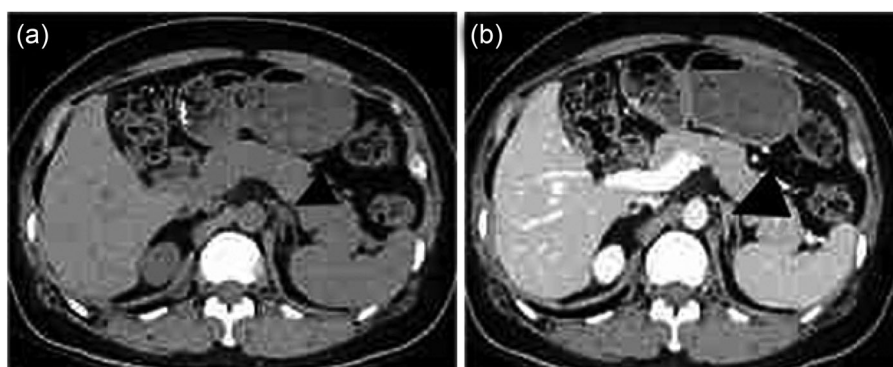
Computed tomography images of the left adrenal gland in patient 1. (A) Plain scan. (B) Contrast-enhanced scan.
